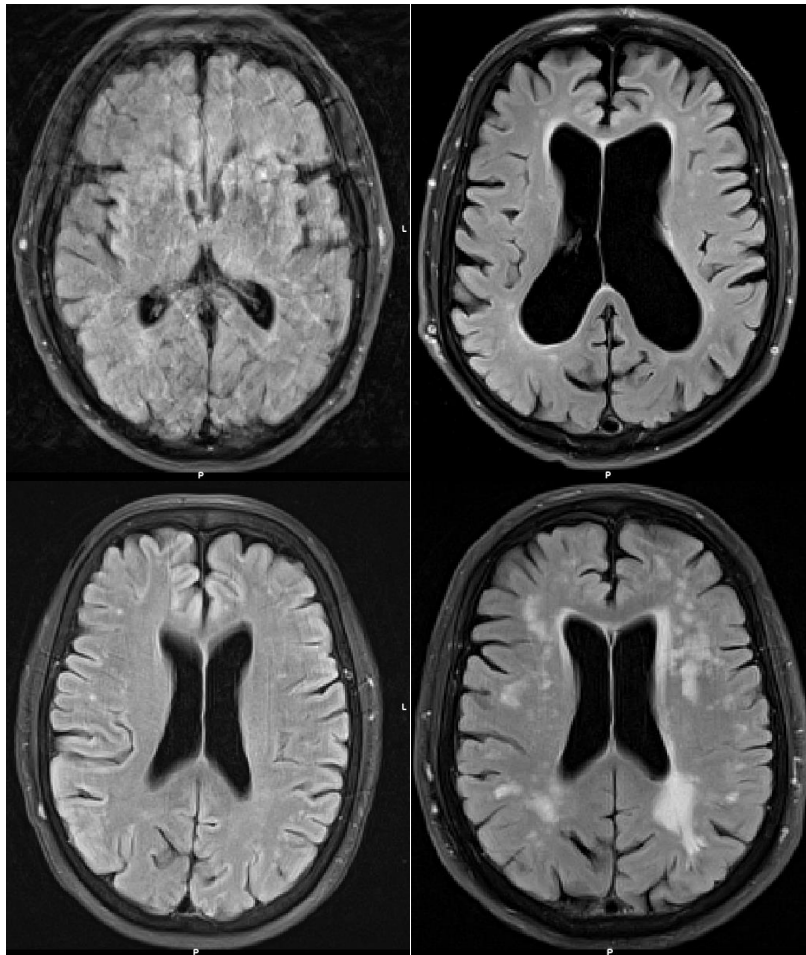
Example of four FLAIR images. The first three are all ineligible for WMH segmentation: the top left scan presents very strong motion artifacts; the top right scan shows extremely big ventricles which prevents the shape of the brain from being considered “regular”; the bottom left scan has visible WMH lesions which, however, are
